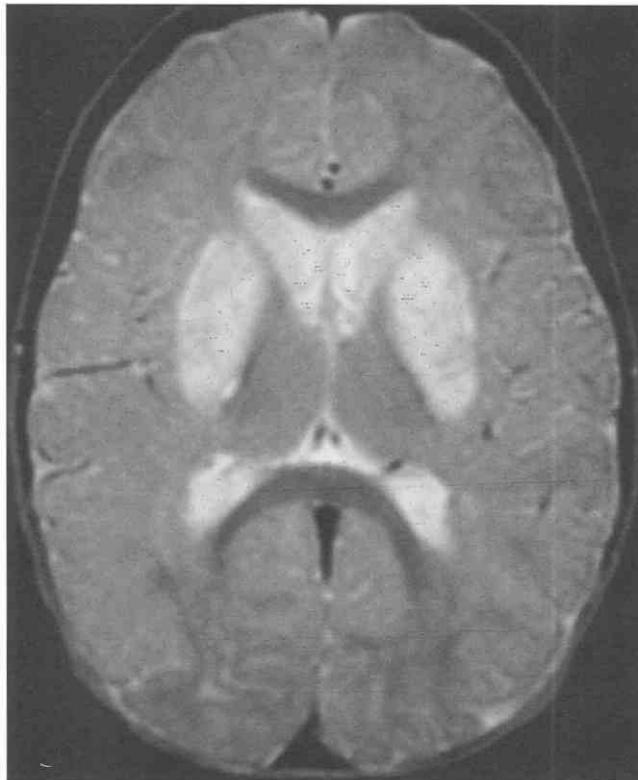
Leigh's disease in an 18-month-old child. T2-weighted axial image shows increased signal in the basal ganglia bilaterally. Some toxic and anoxic injuries can produce a similar pattern of ischemic injury.
